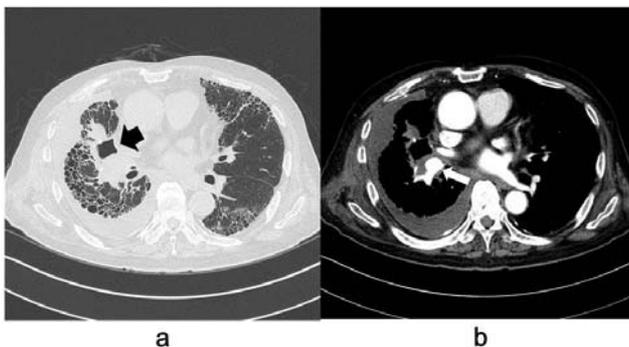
Chest CT shows an air space between the right upper lobe and the lower lobe, which indicates a bronchopleural fistula (black arrow).
